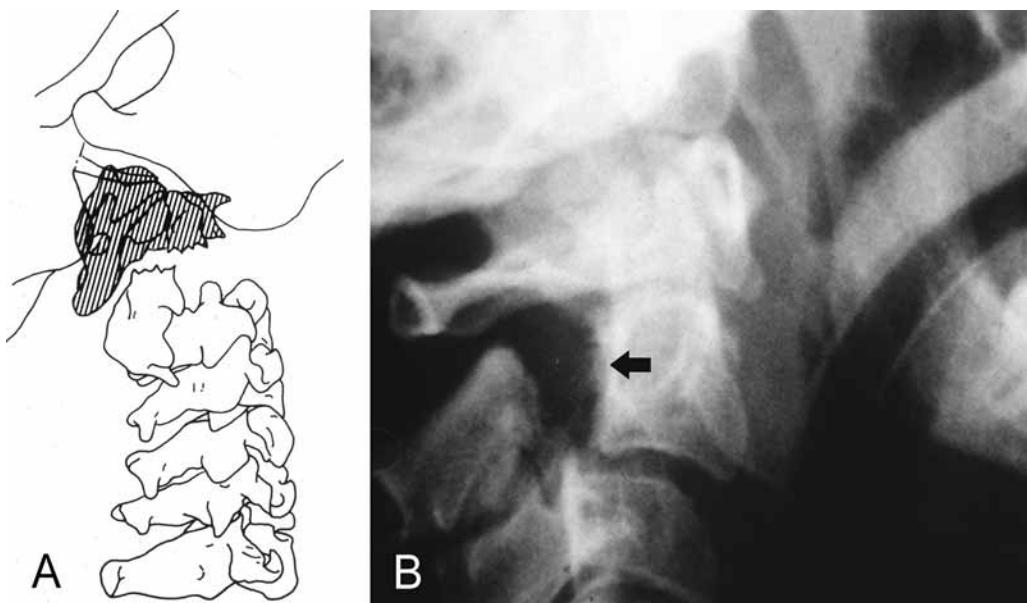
Classical “hangman’s fracture.” (A) Fracture through pedicle of C2 (axis) by hyperextension. Dislocation of C1 (atlas) and vertebral body of C2 (lined) leading to spinal cord trauma and death. (Reprinted, with permission, from ref. 170 and the Journal of Forensic Sciences, Vol. 34, No. 2, copyright ASTM International, West Conshohocken, PA). (B) Radiograph of a “hangman’s fracture” (fracture of pedicle of C2—arrow).
